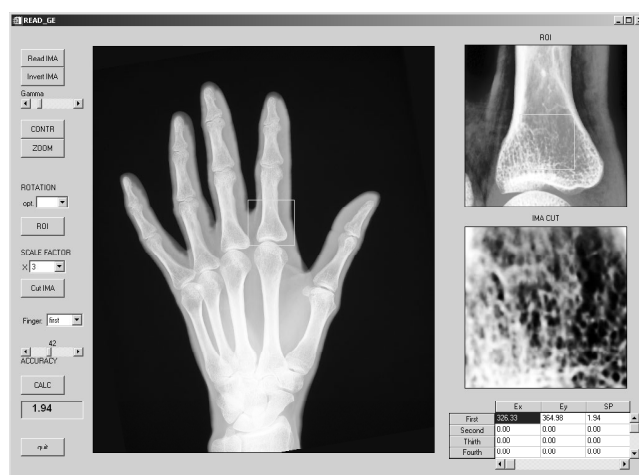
Operator's interface snapshot: radiographic hand image (left), zoom of the region of interest (upper right) and trabecular zone selected for the structural analysis (bottom right)
